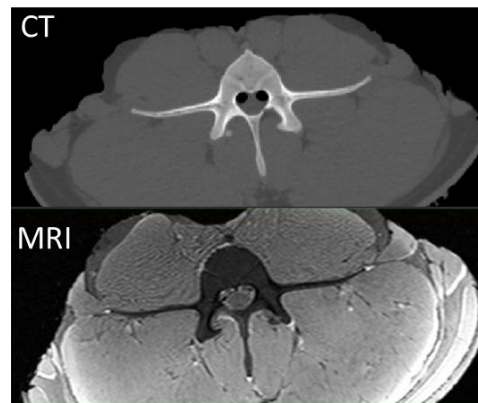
Representative axial slice of vertebra showing visual difference between CT and MR imaging
